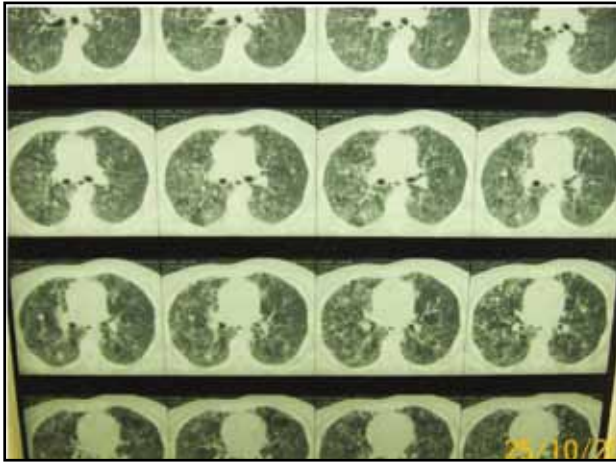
CT Scan of chest showing bilateral reticulonodular lesions
